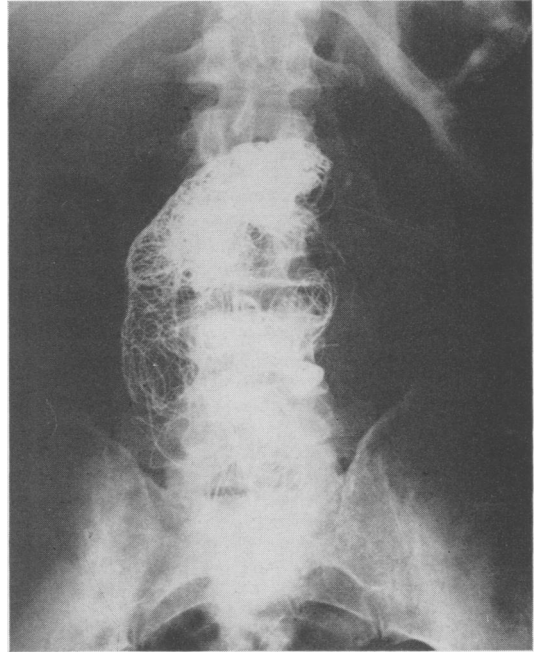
A roentgen ray of the abdomen taken after wiring and electrothermic coagulation of a very large arteriosclerotic aneurysm. The lesion has been stabilized now in excess of eight years since operation. Note concentration of wire at the upper aortic-aneurysm junction for its impedance effect.
